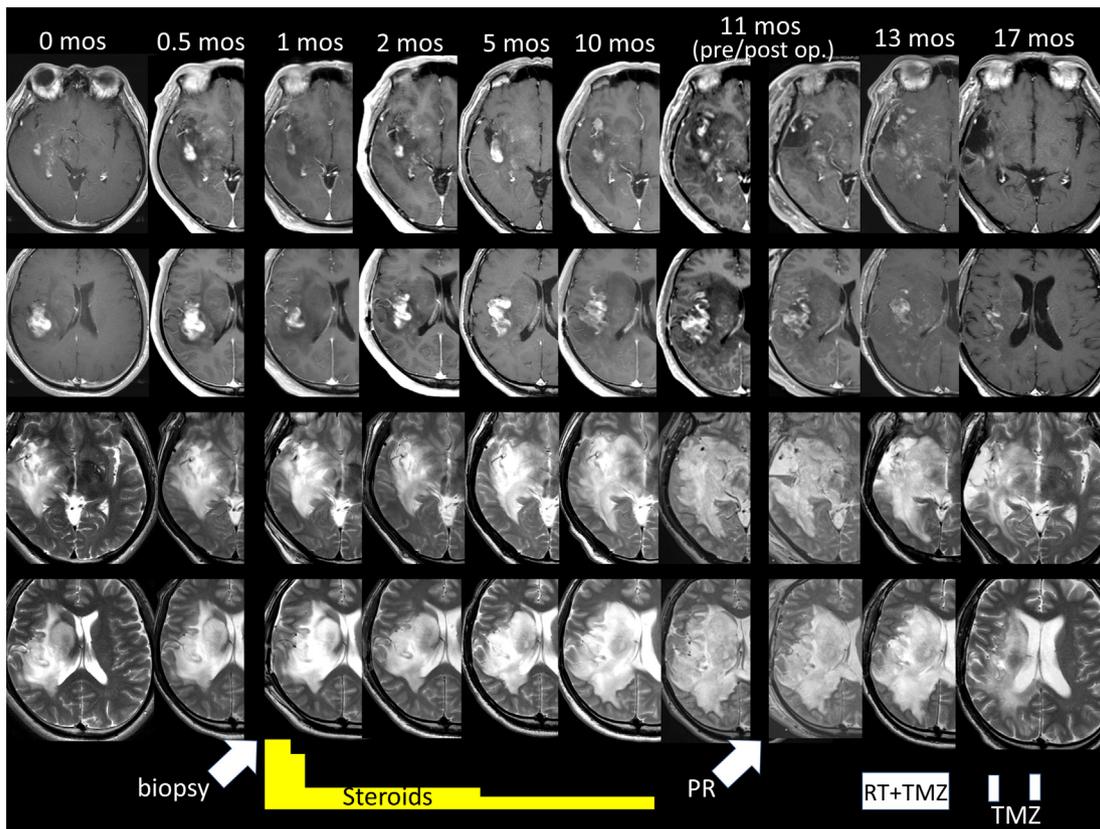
The axial view of MRI (upper and upper middle, T1WI with Gd enhancement; lower and lower middle, T2WI) before and after the biopsy, partial removal (PR) and radiation therapy (RT) concomitant with temozolomide (TMZ) showing the drastic change of tumor lesion.
